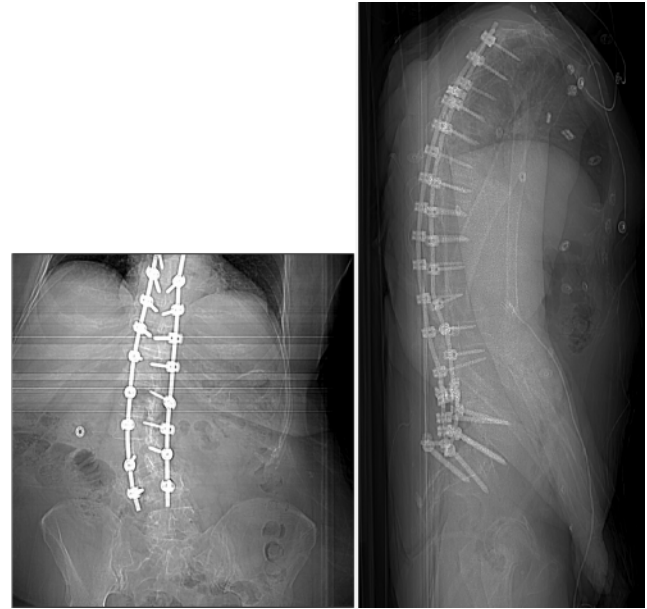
Case 4. Left: Four-month postoperative radiograph demonstrating pseudarthrosis and lateral fixed listhesis at L4–5. Right: Postoperative radiograph demonstrating extension to S-1 and the ilium.
